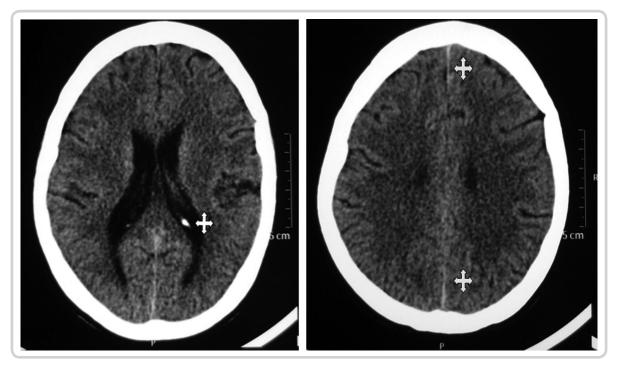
(A) CT scan image showing CSF as black shadow within lateral ventricle—Red coloured quad arrow shows a white spec within the ventricle- choroid plexus in the collateral trigone. (B) CT scan image showing falx cerebri as a thin white line in the midline-yellow quad arrow- Sulci and gyri can be appreciated in the periphery
